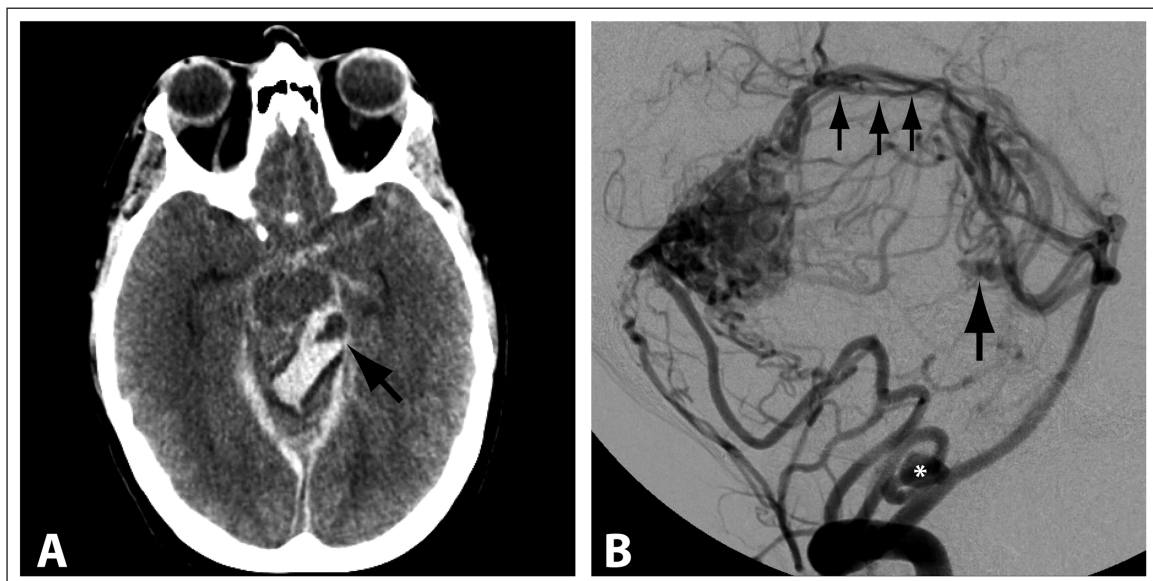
A) CT head showing distal SCA aneurysm (arrow) surrounded by hematoma in the superior vermis. B) Lateral projection of left vertebral artery injection demonstrates PICA origin aneurysm (asterisk), with ruptured distal SCA aneurysm (large arrow), both on vessels supplying a cerebellar AVM. As a result of localized vermian mass effect, the upward arching SCAs and superior vermician branches are elevated through the tentorial hiatus (arrows).
